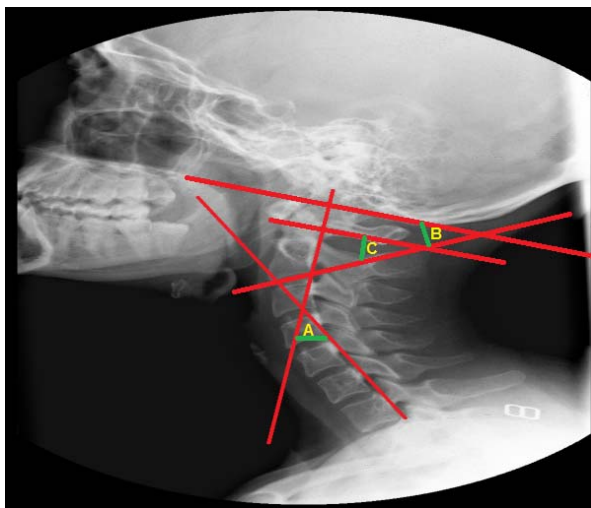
X-ray image to calculate angles of cervical spine using CorelDRAW program, A: Absolute rotation angle (ARA) (C<sub>2</sub>-C<sub>7</sub> angle), B: Occipital to 2nd cervical (Oc-C<sub>2</sub>) angle and C: 1st and 2nd cervical (C<sub>1</sub>-C<sub>2</sub>) angle
